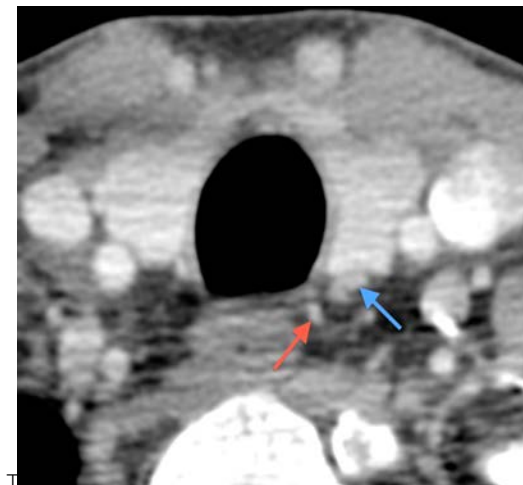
Normal thyroid gland on an axial contrast-enhanced CT image at the level of the cervical trachea. Red arrow (inferior thyroid artery) and blue arrow (inferior thyroid vein).
